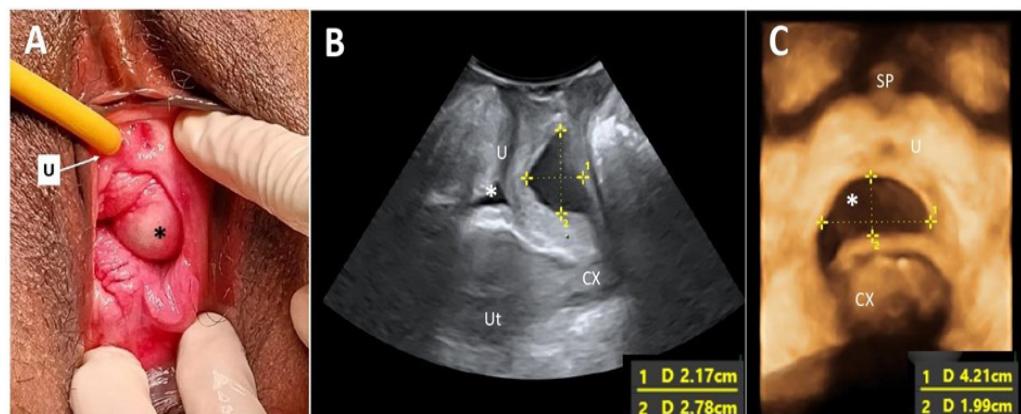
(A) A left periurethral mass extending from the left periurethral space to suburethral region measuring 3 cm x 5 cm; (B) Midsagittal view of the pelvic floor showing a cystic mass (*) dorsal to the urethra (U) measuring 2.17 cm x 2.78 cm on translabial perineal ultrasound (TPUS); (C) TPUS view demonstrating a periurethral mass dorsal to the urethra measuring 4.22 cm (width) x 1.99 cm (vertical dimension). (SP: Symphysis pubis; Ut: Uterus; CX: Cervix)
